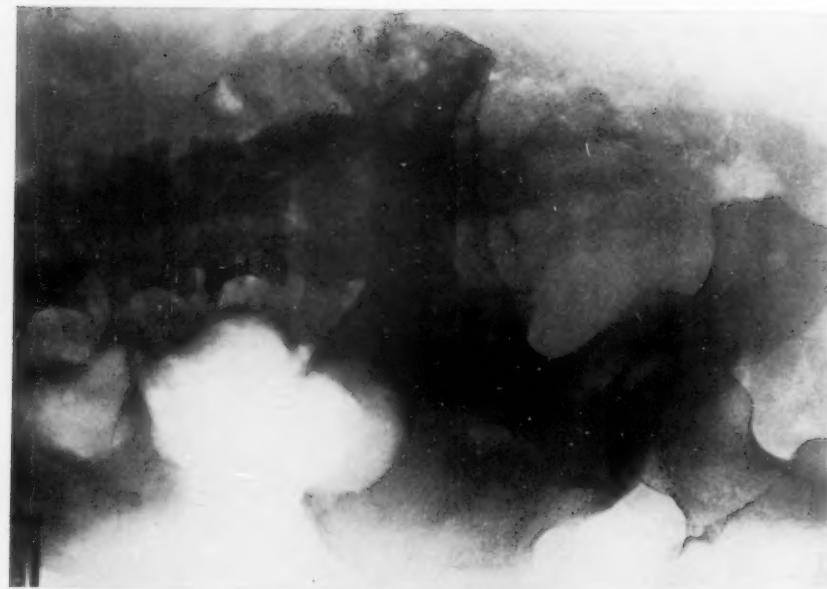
Post-operative X-ray of the first patient, showing the loss of the pelvic bones from symphysis pubis to sacro-iliac joint.
